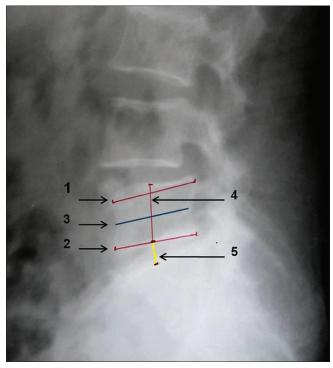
Measurements done on lateral view of lumbosacral spine X-ray. 1: Superior vertebral end plate, 2: Inferior vertebral end plate, 3: Mid-anteroposterior diameter, 4: Height of body of L5, 5: L5–S1 disc height
